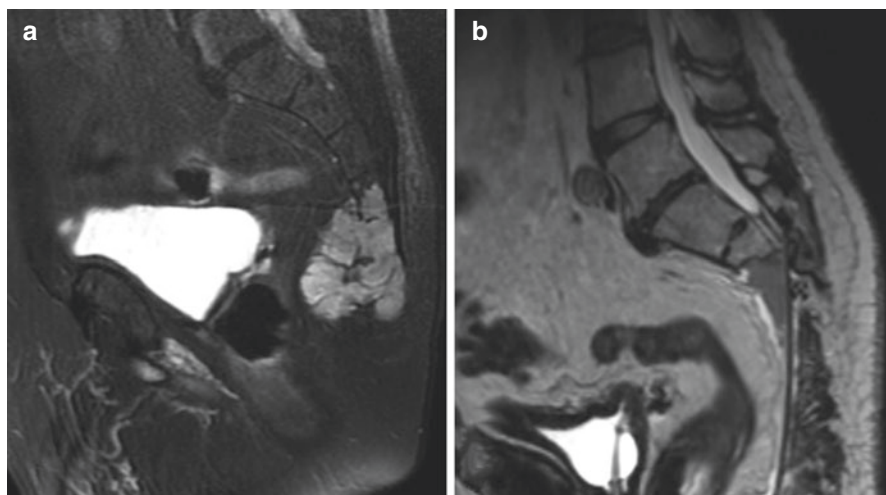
(a) MRI pelvis fat suppression sagittal sequence demonstrating a T2 hyperintense distal sacral chordoma. (b) MRI T2 image showing a mid-sacral amputation for en bloc resection of the chordoma
